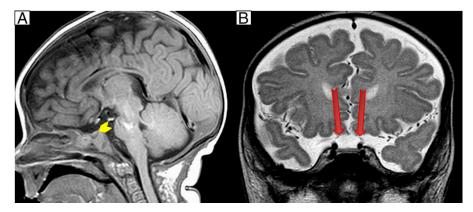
Brain magnetic resonance imaging. A. Sagittal T1-weighted image. The pituitary gland (yellow arrowhead) is diminutive in size and hypointense. A normal pituitary stalk is not visualized, indicating an ectopic neurohypophysis. B. Coronal T2-weighted image showing optic nerve hypoplasia (red arrows).
